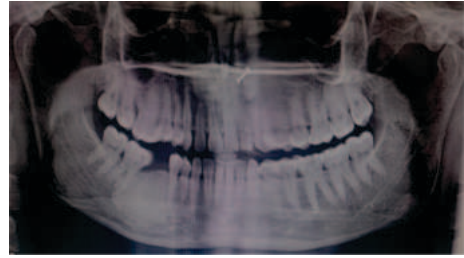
Panoramic Radiograph Revealing Enostosis in the Edentulous Area with 46.
